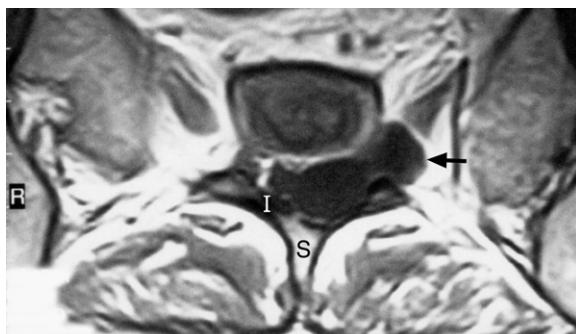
S1-2 level MRI axial image showing a dumbbell type cystic lesion with no enhancement or CSF signal intensity extending into the left half of the spinal canal and through the left S1-2 neural foramen (arrow). I = intermediate crest of the sacrum; S = spinous tubercle of the median crest.
